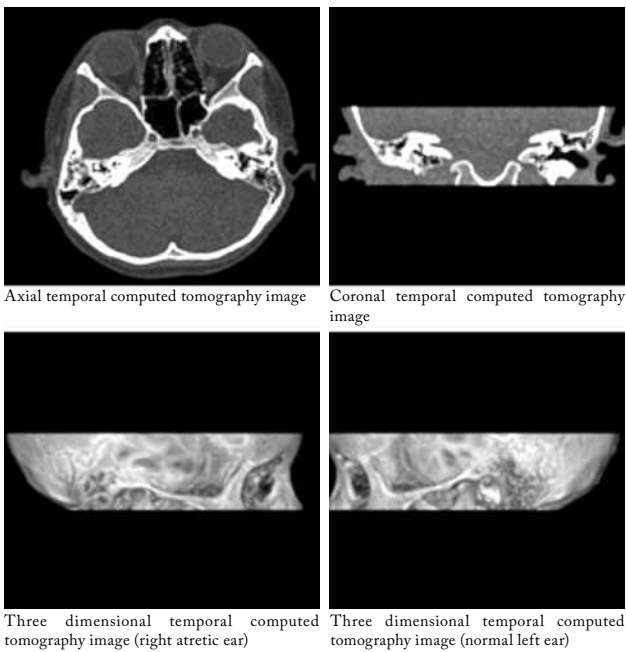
Temporal computed tomography and three-dimensional images of patients.
